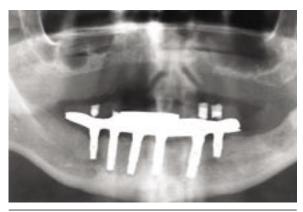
Postoperative x-ray of completed implant
